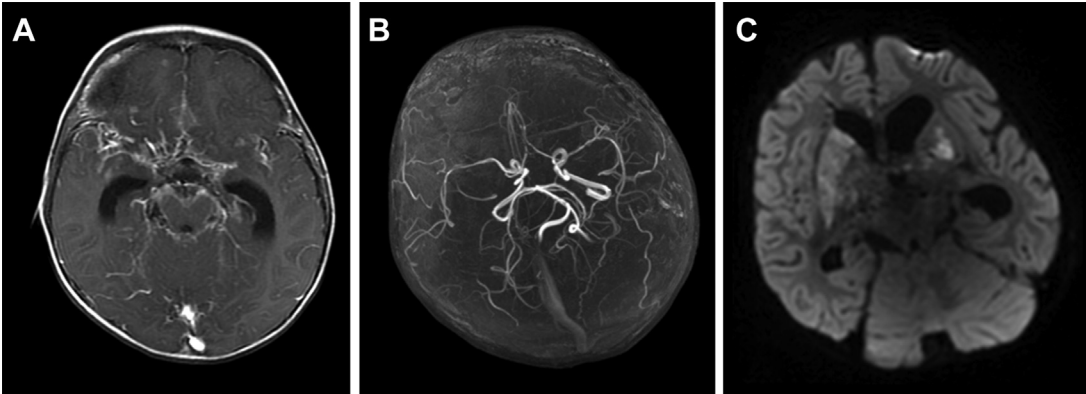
Tuberculous meningitis with secondary acute infarction. Axial T1-weighted postcontrast MR imaging shows extensive enhancement in the basal cisterns (A). On time-of-flight MR angiography, there is luminal irregularity in the bilateral middle cerebral artery (MCA) (B). Axial DWI shows multifocal acute infarctions in the bilateral basal ganglia and thalamus (C).
